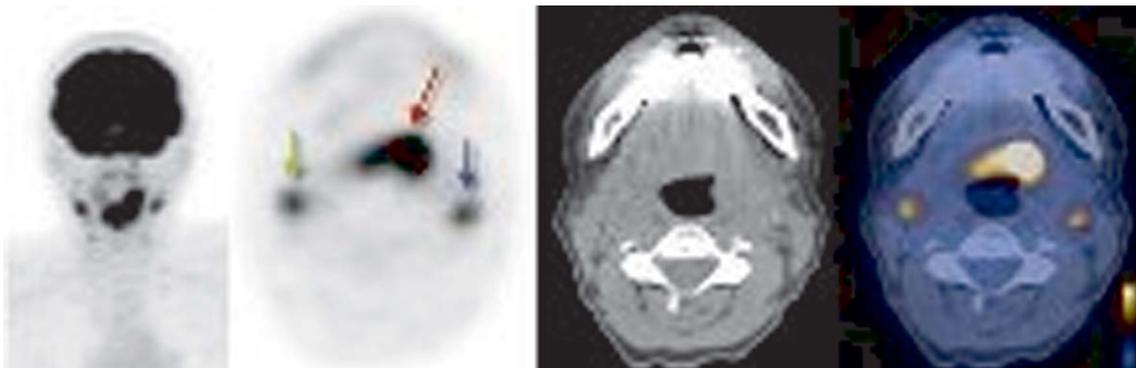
Squamous cell cancer of the left vallecula, midline crossing, bilateral lymph node metastasis. From left to right: "Maximum intensity projection" PET image (MIP), axial PET, CT, and fused PET/ CT. SUV primary tumor 9.7 (red arrow), ipsilateral lymph node 4.1 (blue arrow), contralateral lymph node 4.3 (green arrow).
